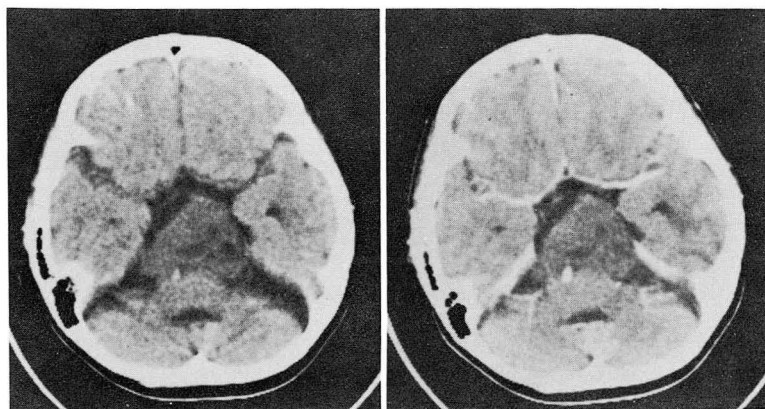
Axial CT scan shows a large isodense mass in the basal cistern, and no evidence of enhancement in post-contrast scan.
